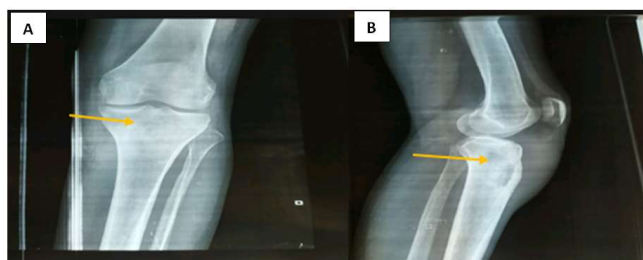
Plain radiographs of the left knee at presentation.
